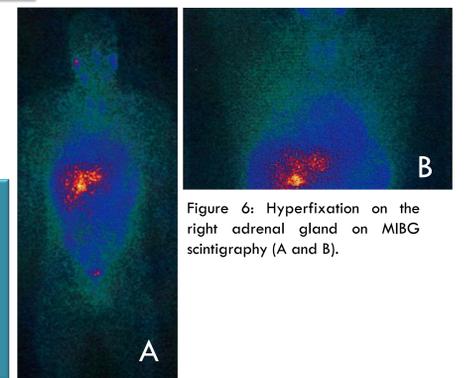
Hyperfixation on the right adrenal gland on MIBG scintigraphy (A and B).
